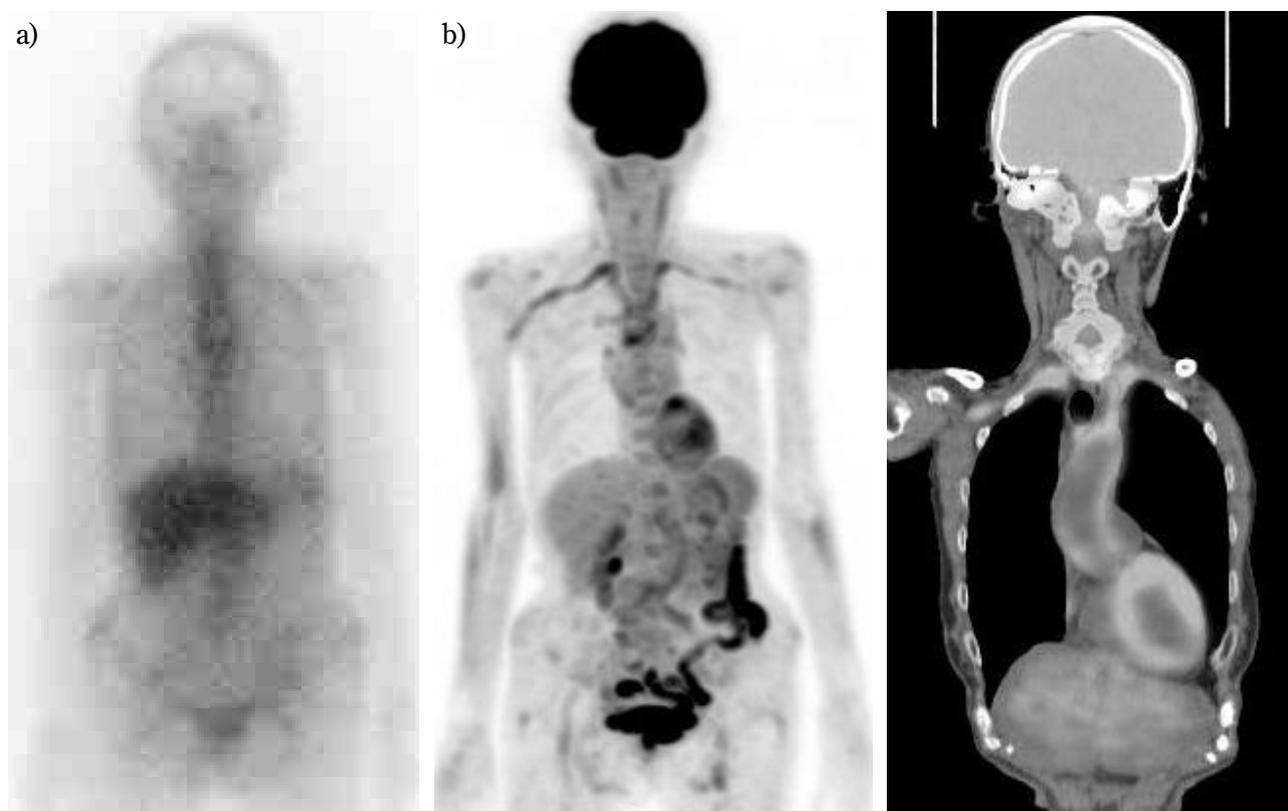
A 77-year-old female. a) ^{67}Ga -citrate scintigraphy shows no abnormal uptake. b) MIP image of FDG-PET. c) MPR image of PET/CT. FDG-PET/CT scan demonstrated intense FDG uptake in the walls of the thoracic aorta, abdominal aorta, carotid arteries and iliac arteries.
